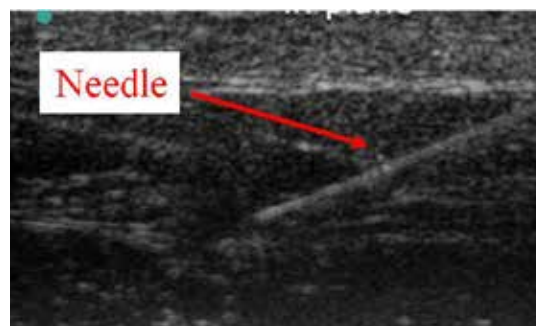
Ultrasound imagery being used to place a needle into the ligament for PRP/Prolotherapy.
